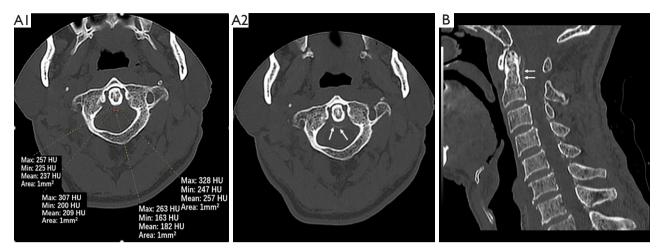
Case 2. The other patient with CDS, a 65-year-old man, in whom all CT findings resemble those of case 1. Axial (A1, A2) CT image unenhanced neck CT images (window level: 500 HU; window width: 2,000 HU) show lined-calcifications around the dense (A2 arrows), the mean CT number 182–257 HU (A1). Sagittal (B) MPR imaging (500 HU; 2,000 HU) shows lined-calcifications at the posterior and superior aspects of the dens (arrows). CT, computed tomography; CDS, crowned dens syndrome; MPR, multi-planar reformatting.
